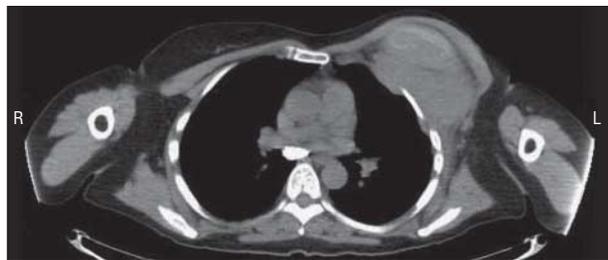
Computed tomography of the chest showing a left subpectoral mass. R indicates right; L, left.
